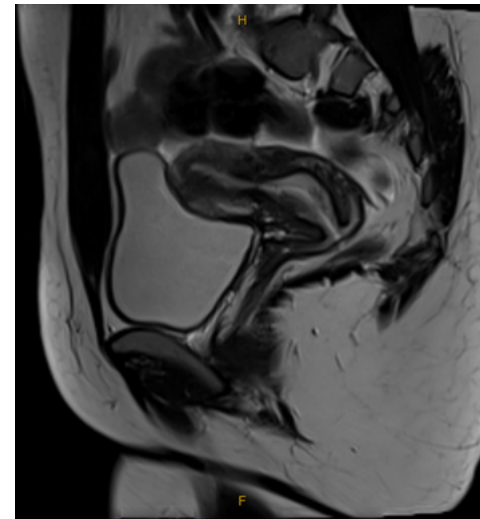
Initial MRI post D&C
